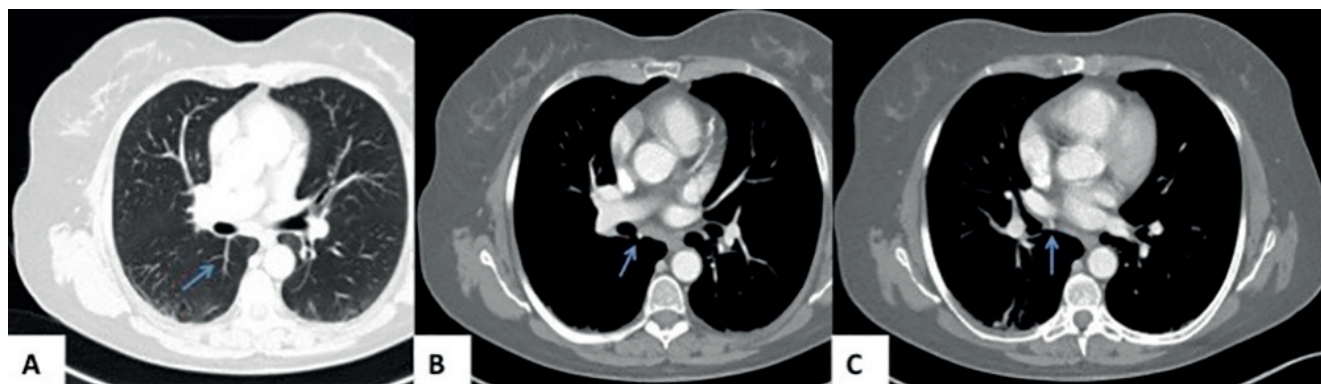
Preoperative chest computed tomography (CT) scans. A-C) Segmental pulmonary vein from the superior segment of the right lower lobe running behind the bronchus intermedius and joining the superior pulmonary vein (blue arrow).
